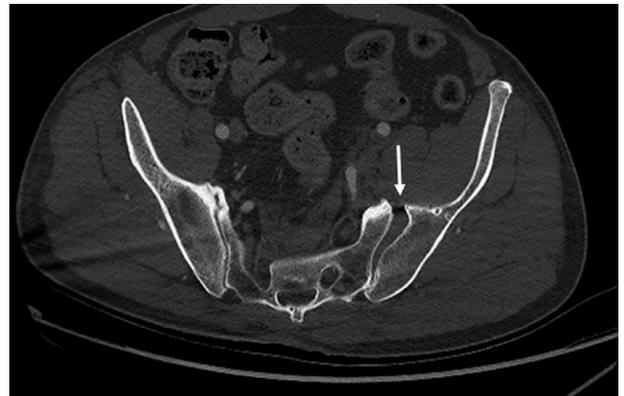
Axial CT of the pelvis in Grade III anteroposterior compression injury: anterior widening of left sacroiliac joint.
